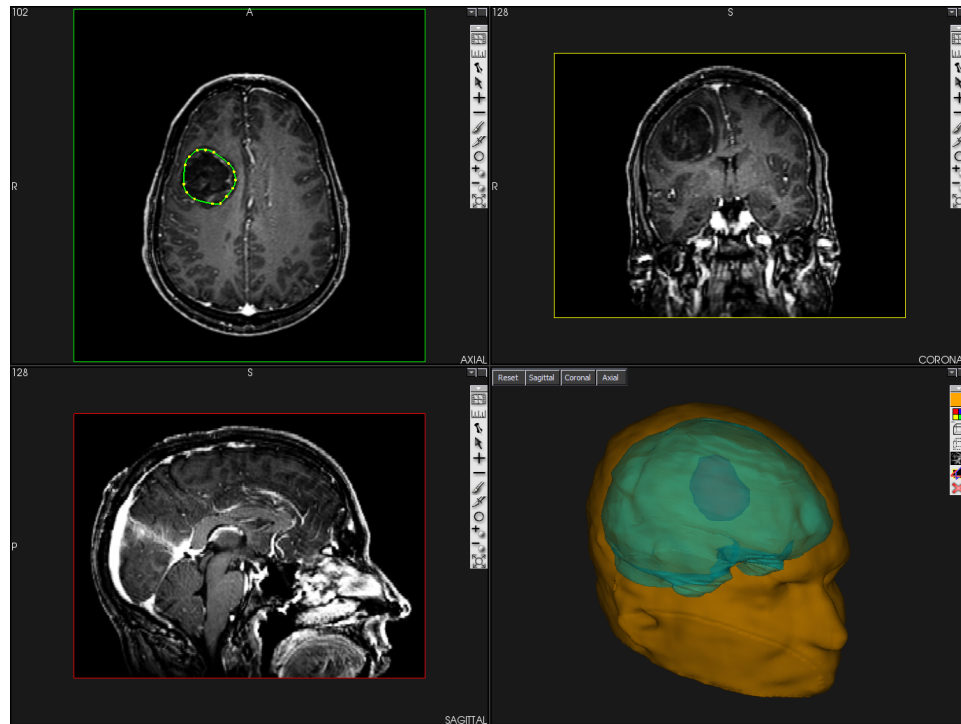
Screenshot of the surgical planning software interface displaying the three views of the MRI image data: axial, sagittal, and coronal. The tumor area is marked with the contouring tools in the axial view (top left). The separated 3D head, brain, and tumor model are rendered in the bottom right window with different colors.
